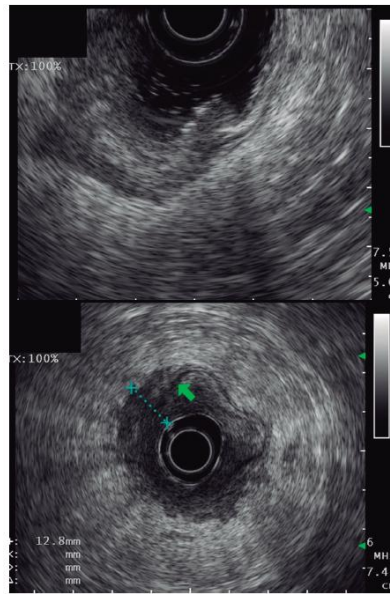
Endoscopic ultrasound assessment of the primary tumor (T) according to the TNM classification in rectal cancer.
